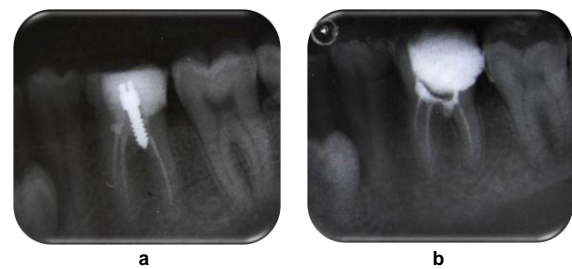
Pre-operative radiograph of 36 (a), post-operative radiograph of 36 after repair of the perforation (b)
